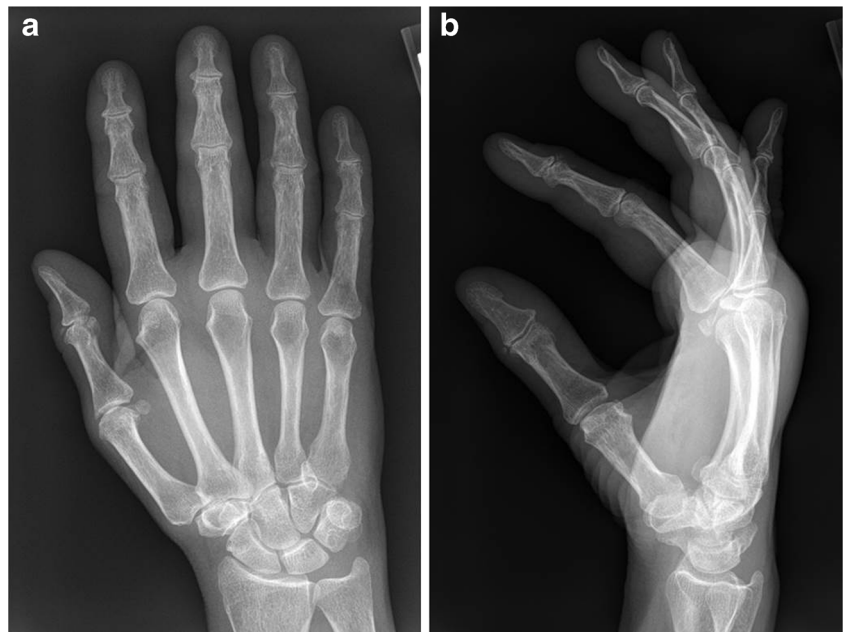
a Anteroposterior and b lateral radiographs at the time of presentation
